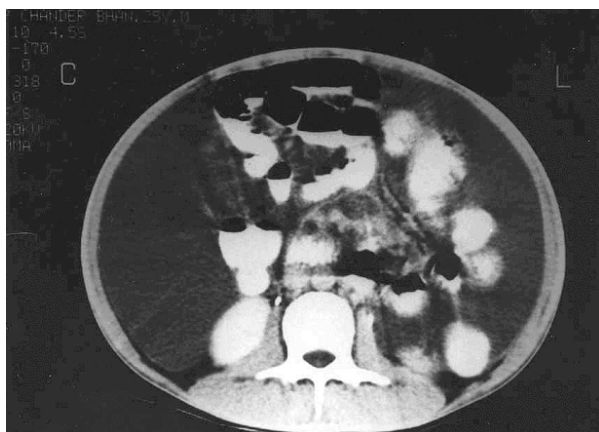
Abdominal CT scan showing acute pancreatitis (Grade E).
